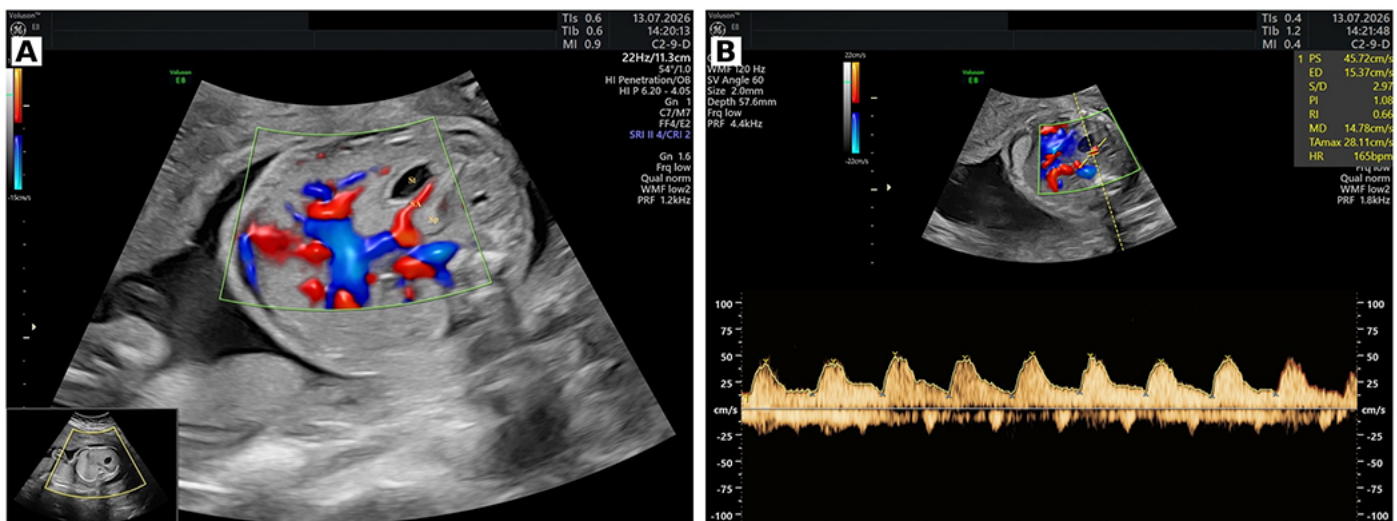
Ultrasonographic visualization of the fetal splenic artery (SA). (A) Color Doppler image showing the SA arising from the celiac trunk and coursing along the superior border of the pancreas toward the splenic hilum (St, stomach; SA, splenic artery; Sp, spleen). (B) Pulsed-wave Doppler waveform of the SA obtained at an insonation angle <30°, with corresponding velocimetric parameters.
